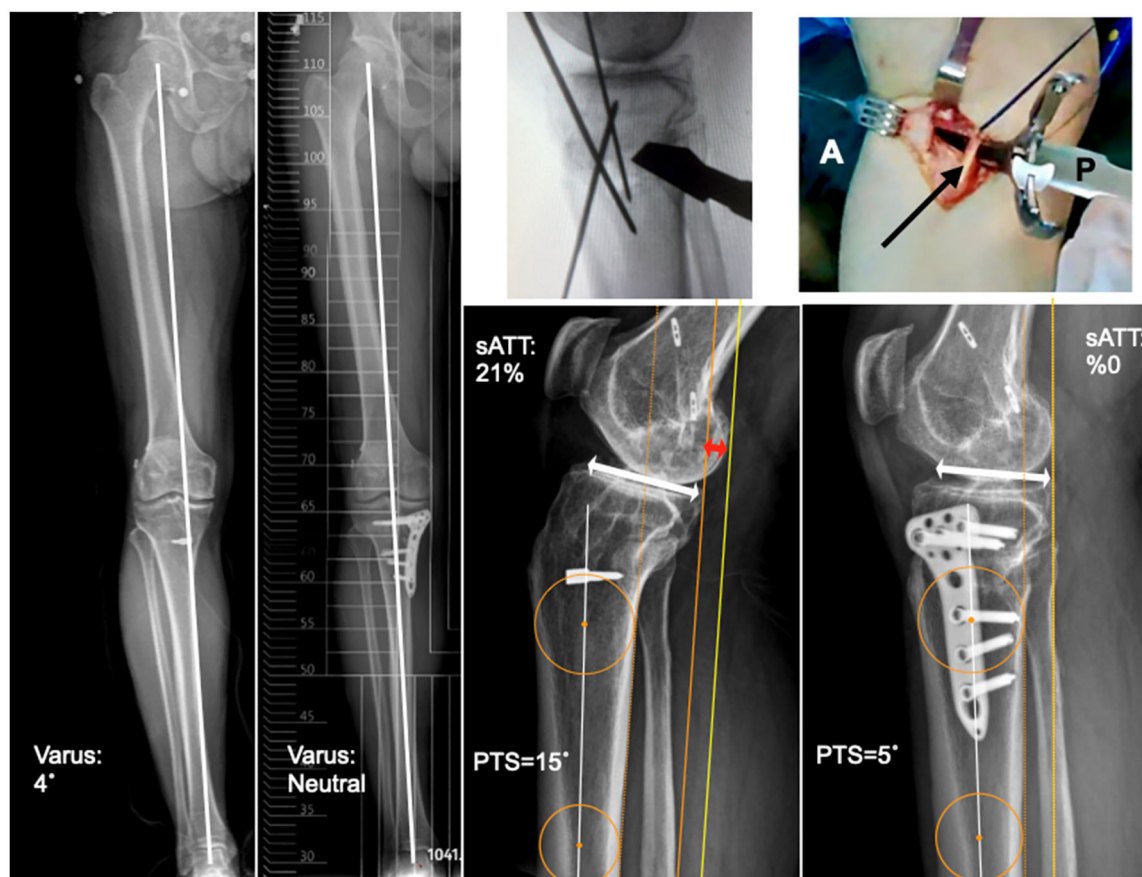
Biplanar correction of concurrent coronal and sagittal decompensation using a medial opening wedge high tibial osteotomy (MOW-HTO). Preoperative and post-operative imaging of a patient presenting with a symptomatic varus deformity and concurrent sagittal instability. (Left) Preoperative long-leg standing anteroposterior (AP) radiograph demonstrates a 4° varus mechanical axis deviation, which is successfully corrected to a neutral axis post-operatively. (Bottom Right) The corresponding preoperative monopodal weight-bearing lateral radiograph reveals a highly hostile sagittal profile with a steep posterior tibial slope (PTS) of 15° and a profoundly elevated static anterior tibial translation (sATT) of 21%. Following the MOW-HTO, post-operative imaging confirms the PTS is reduced to 5°, successfully neutralizing the sagittal shear vector and recentering the sATT to a physiological 0%. (Top Right) Intraoperative technique for the biplanar MOW-HTO. The clinical photograph demonstrates the posterior opening of the osteotomy, with the black arrow indicating the medial collateral ligament (MCL) and a spreader placed behind it (A: anterior, P: posterior). The accompanying fluoroscopic image demonstrates anterolaterally placed protective K-wires utilized to allow for controlled PTS reduction while safely protecting the lateral hinge.
